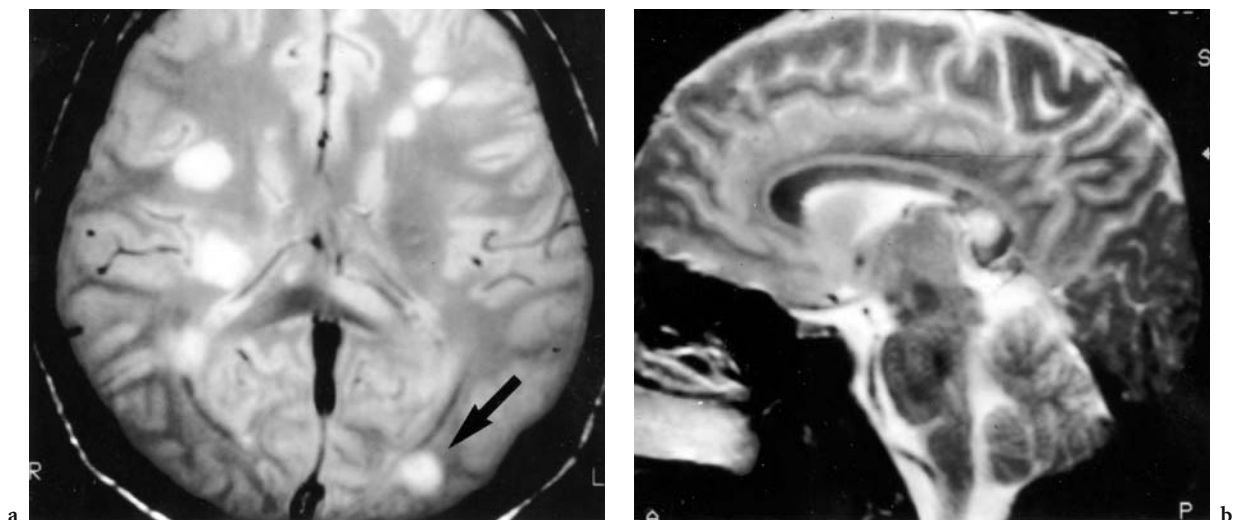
MRI of a 21-year-old man with known multiple sclerosis and an acute sensomotoric symptomatology, but no visual deficit. a Axial PD view, showing the disseminated inflammation areas with typical ovoid to spherical configuration in the periventricular white matter, in the area of distal left optic radiation (*arrow*), and in the posterior left splenium. b Sagittal T2-weighted view, where the demyelination of the posterior corpus callosum is visualized
